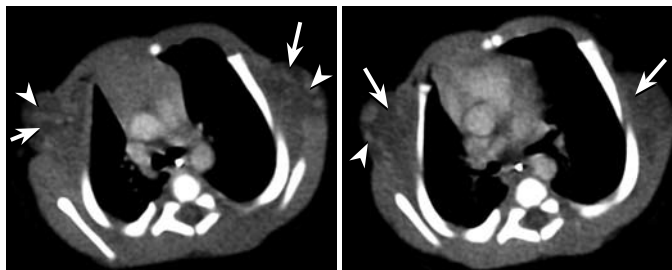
CT of the chest demonstrates bilateral fat density (*arrows*) with nodular enhancement (*arrowheads*) in the axilla and along the lateral chest.
